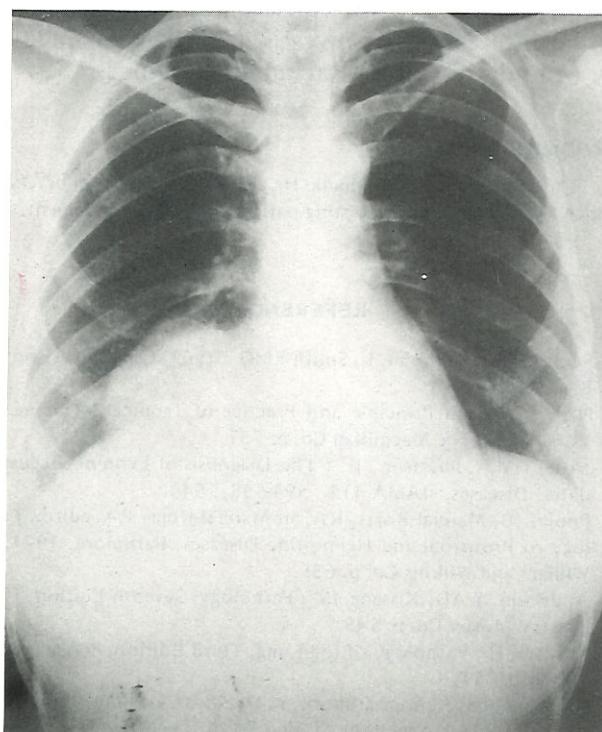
Chest x-ray showing a well-defined mass over the right lower lobe of the lung.
